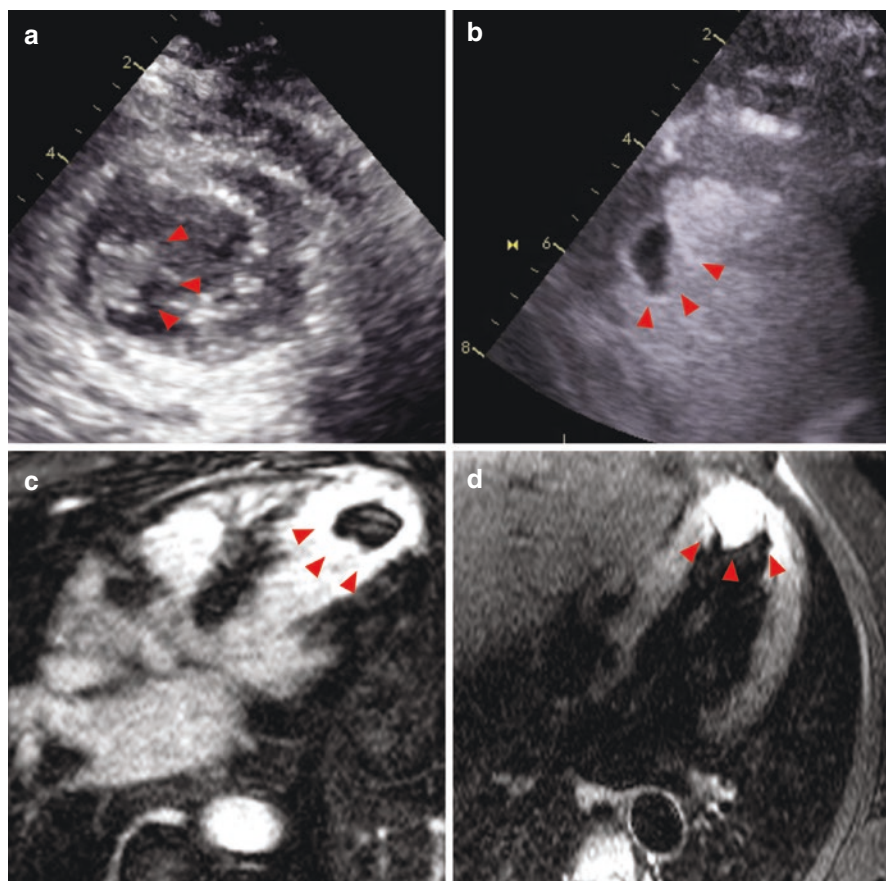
Left ventricular thrombus with different diagnostic tools. Small-size apical LVT appears as an echo-dense mass on transthoracic echocardiography (a) and more delineated after intravenous contrast medium (b). Cardiac magnetic resonance imaging: LVT on delayed-enhancement image, four-chamber view (c), and turbo inversion recovery magnitude (TIRM) sequence of the same view on showing high signal in the apical segments of the left ventricle consistent with myocardial edema and apical thrombus (d)
